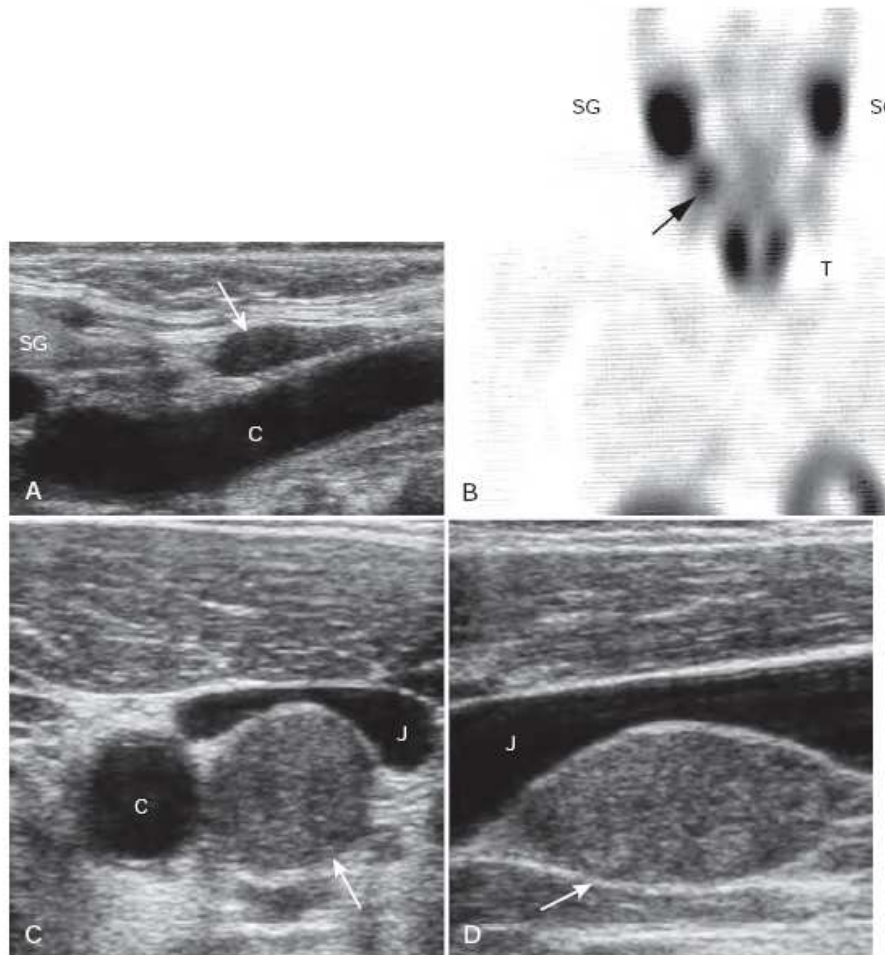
Ectopic parathyroid adenoma: near carotid sheath. A, Longitudinal sonogram of right side of the neck shows an ectopic undescended parathyroid adenoma (*arrow*) external to the carotid sheath, anterior to the common carotid artery (*C*). Ultrasound-guided biopsy confirmed parathyroid tissue before surgical exploration. *SG*, Submandibular gland. B, Scintigraphy using technetium-99m sestamibi and coronal SPECT imaging shows a focal area of increased activity in right superior lateral neck
